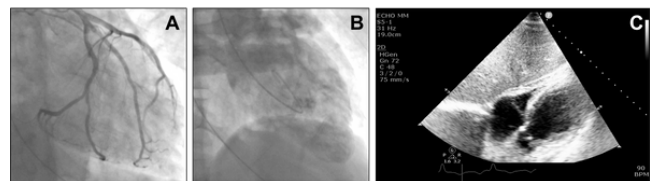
Coronary angiography and transthoracic echocardiography
